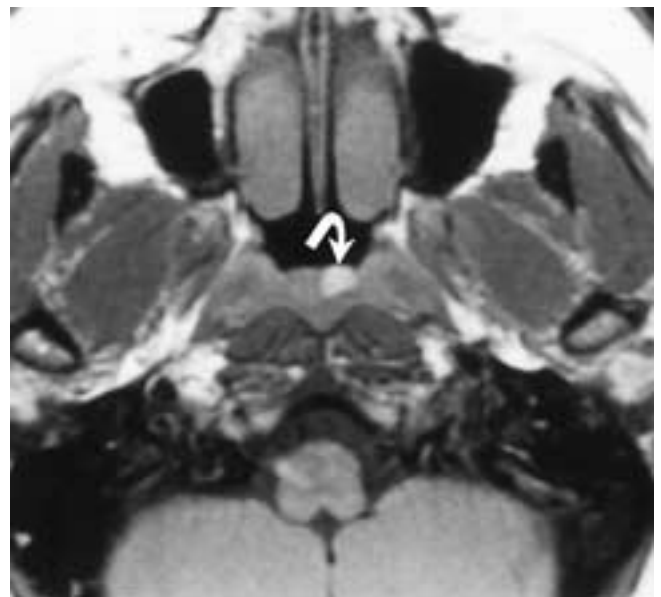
Noncontrast axial T1-weighted MR image demonstrates a high signal intensity, round lesion (*arrow*), with well-defined margins, located just at and deep to the mucosa of the nasopharynx. This was a retention cyst, and the increased signal was due to the high protein content of the cyst fluid.
